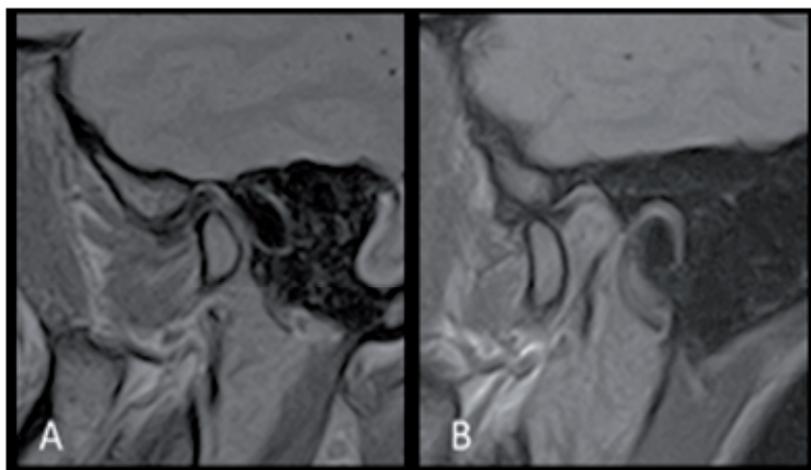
Sagittal images on MRI showing normal TMJ disc position: A) closed mouth; B) open mouth
